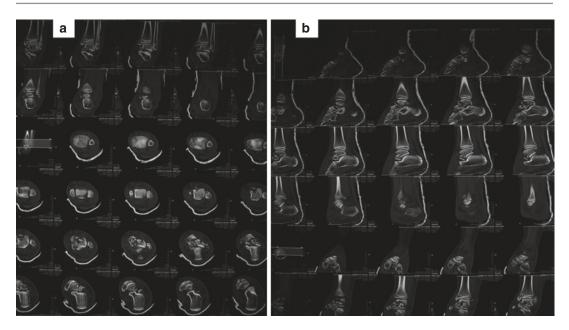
(a) Axial and (b) sagittal CT cuts showing the fracture morphology and topography
